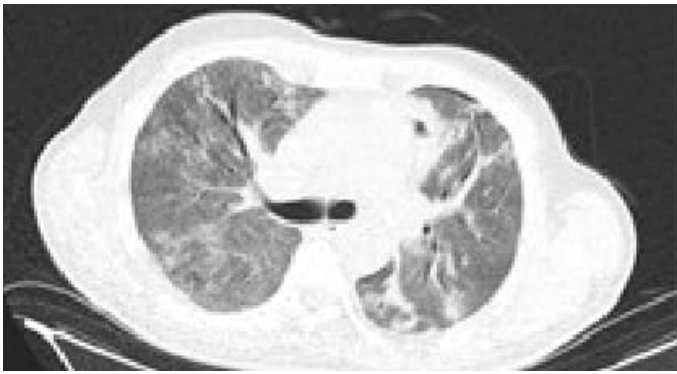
Thoracic computed tomography scan showing consolidated areas with ground glass opacities at the time of admission (left) and ground glass opacities widely covered the whole lung after administration of convalescent plasma treatment (right).
